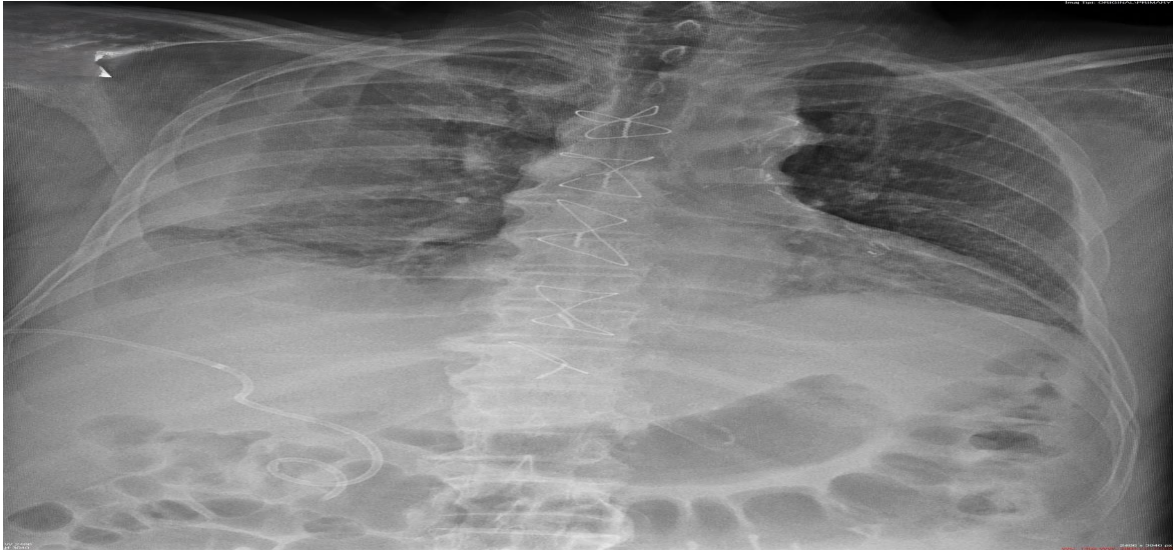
Posterior-anterior chest radiography
